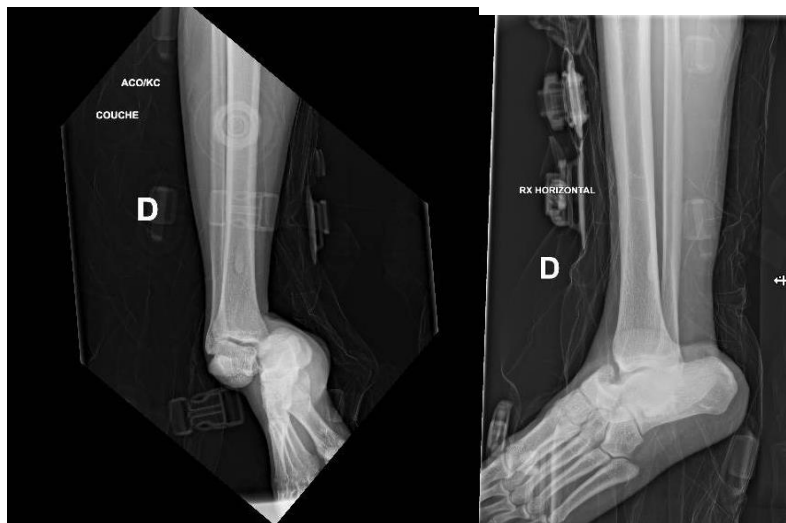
Antero-posterior and lateral radiographs of the right ankle showing an isolated medial subtalar joint dislocation with the calcaneus and the rest foot dislocated medially in relation to the talus.
